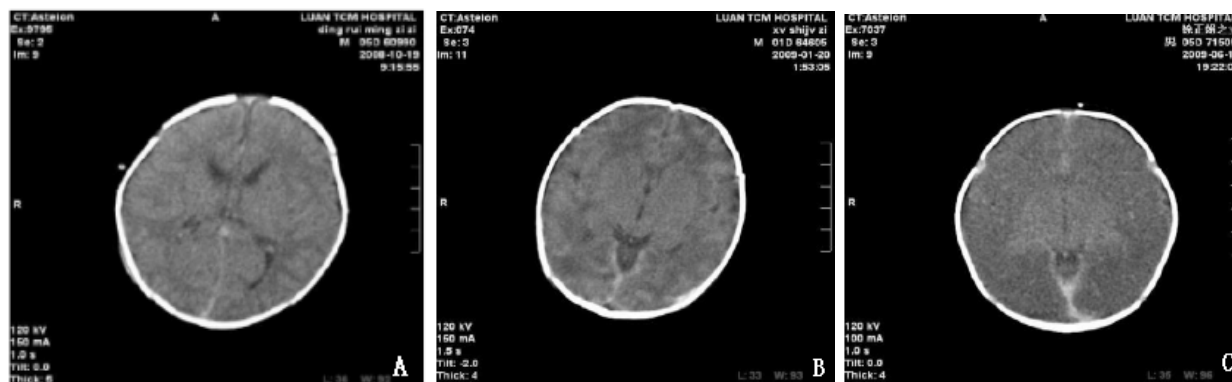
CT diagnostic results. *A)* mild hypoxic ischemic encephalopathy: local low-density area in the left frontal lobe; normal ventricle, but with little subarachnoid hemorrhage; *B)* medium hypoxic ischemic encephalopathy combined with subarachnoid hemorrhage: focal low-density area in the bilateral frontal lobes and temporal lobes; fuzzy boundary between brain gray matter and white matter; subarachnoid hemorrhage; surrounding sulcus and fissures are narrowed; *C)* severe hypoxic ischemic encephalopathy: diffuse low-density area in lobes of brain solid; fuzzy boundary between brain gray matter and white matter; normal density of basal ganglia and dorsal thalamus; compressed paracene; disappearance of sulcus and fissures.
